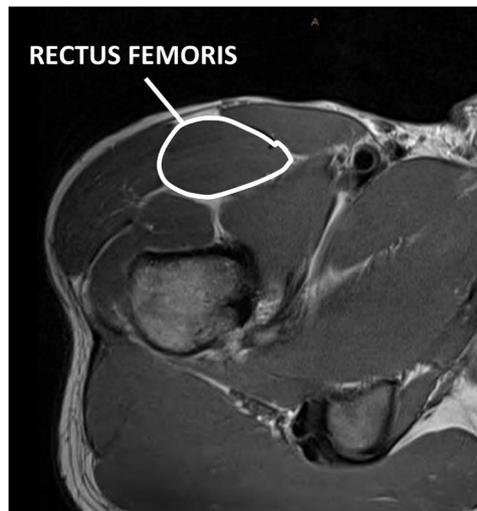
Rectus femoris muscle cross-sectional area traced on an axial T1 MRI.
